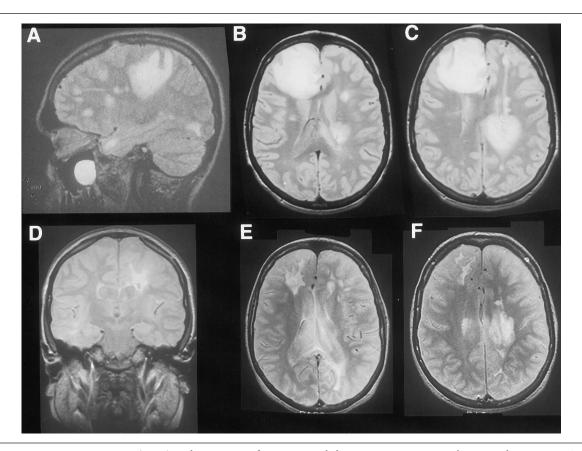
Magnetic resonance images (MRIs) and case report of a patient with biopsy-proven pattern III lesions at disease onset. Case report: This 22-year-old woman presented in May 1988 with a 2-week history of progressive right-sided weakness. MRI revealed multifocal lesions associated with mass effect, which were suspected for tumor (ie, lymphoma, multicentric glioma, metastasis). The patient underwent stereotactic brain biopsy of the left cerebral lesion, which revealed active demyelination. She dramatically improved after a course of steroids, and by August she was walking independently with minimal residual deficit. In October of that year, she had a second exacerbation characterized by increasing right-sided weakness, which improved after 2 weeks on another course of oral steroids. In January 1989, she experienced a third exacerbation associated with increasing incoordination and tremor of the right upper extremity, migratory paresthesias, and diurnal fatigue. She responded to another course of steroids. In December 1989, she developed a fourth exacerbation with increasing gait difficulties and falling. Examination revealed increase in right lower extremity weakness, which again markedly improved after a course of steroids. In February 1990, she experienced a 3-week episode of hemisensory loss on the left, which resolved spontaneously. In March 1990, she had her sixth exacerbation, which was characterized by profound right arm weakness associated with left-sided trigeminal neuralgia. She improved on a 5-day course of intravenous steroids. She was stable until September 1991, when she experienced another exacerbation characterized by vertigo, increased right arm weakness, and spasticity. Symptoms resolved over 4 days. In October 1991, she complained of a 2-week episode of a new visual scotoma on the right, which again resolved spontaneously. In 1992 she was enrolled in the sulfasalazine clinical trial for relapsing-remitting multiple sclerosis. She was stable with no further exacerbations until 1994, when she had a 3-week episode of right-sided painful tonic spasms. At last follow-up in 1996, her examination revealed minimal right hemiparesis and minimal right lower extremity spasticity. The remainder of the examination was unremarkable. MRI results: Initial MRI examination of the head, dated June 1988, demonstrates multiple large areas of T2 signal abnormality in the white matter of both cerebral hemispheres (A-C). The largest are located in the anterior right frontal region and extend into the genu of the corpus callosum and left parietal region. There is considerable mass effect associated with both lesions. There are several additional periventricular lesions oriented perpendicularly to the axis of the lateral ventricles. Follow-up MRI, dated November 1989, demonstrates residual T2 signal abnormality in the deep left posterior frontal anterior parietal region (D). Another follow-up MRI, dated September 1991, reveals almost complete resolution of the large lesion that was present in the right subfrontal white matter area and considerable decrease in size of the large left posterior frontal anterior parietal white matter lesion (E, F). There are numerous foci of increased T2 signal abnormalities in a pattern consistent with demyelinating disease.
